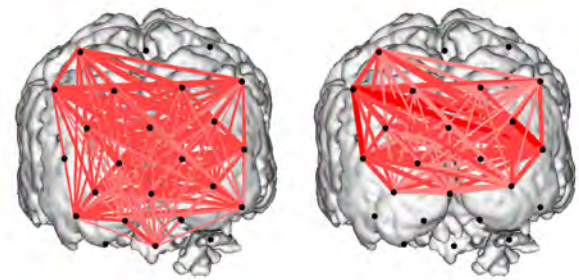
Cortical networks from a representative subject for control (left) and CGC guidance (right). Channel locations (black circles) are overlain onto a reference MRI. Connections are depicted as red lines with strength indicated by thickness of line.
